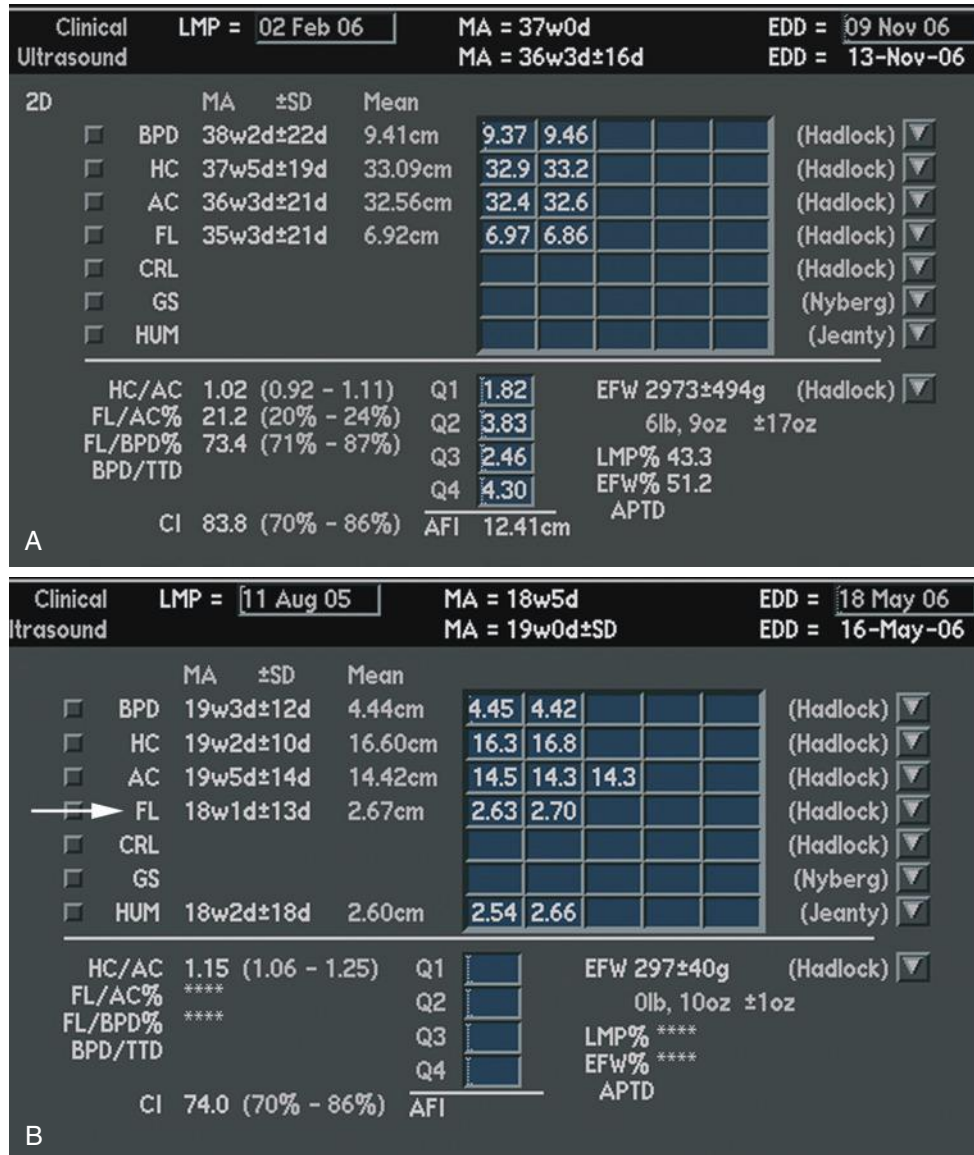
Significance of short femoral length. A, In the mid to late third trimester, it is not unusual for the femur to be significantly shorter than the other measurements used to estimate gestational age. In this case, the femur is approximately 2 weeks less than the head circumference and menstrual age. The cause of this is uncertain, and the short femur is often attributed to biologic variation or ethnicity. If the bones appear normal morphologically and no anomalies are seen, it is likely a normal variant. This fetus was from white parents of normal height and middle socioeconomic status. B, Although the femur can be smaller than other measurements in the third trimester, it is not acceptable for it to be greater than 1 week less than the other measurements in the late first and early to mid second trimesters, as it was in this case (*arrow*). Although this deviation may be nothing more than a temporary growth lag or normal variation at this stage, it may also be a sign of trisomy 21 or an early manifestation of a short-limb skeletal dysplasia. This was a case of trisomy 21. One should not take comfort in comparing the femur measurement to the estimated gestational age by ultrasound imaging. Remember that, unless excluded, the femur measurement is included in the sonographic estimation of gestational age.
